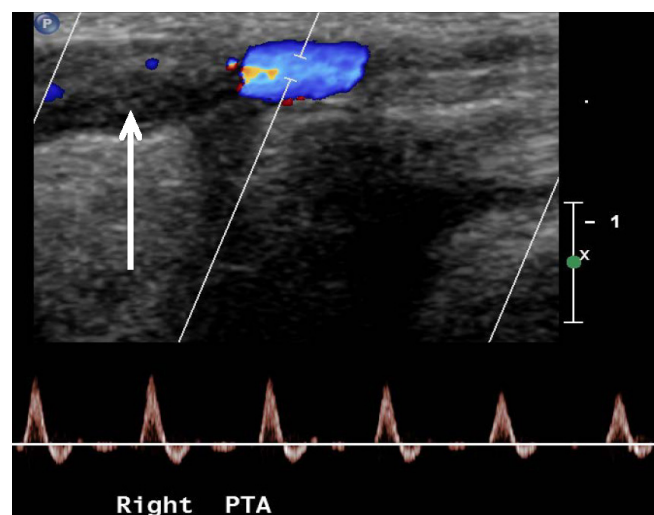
Calcific deposits in right posterior tibial artery deposits of Athlete 3 [Note deposits cause shadowing, resulting in only partial visualisation of the colour Doppler flow. The Doppler spectral trace of flow is, however, normal.]
